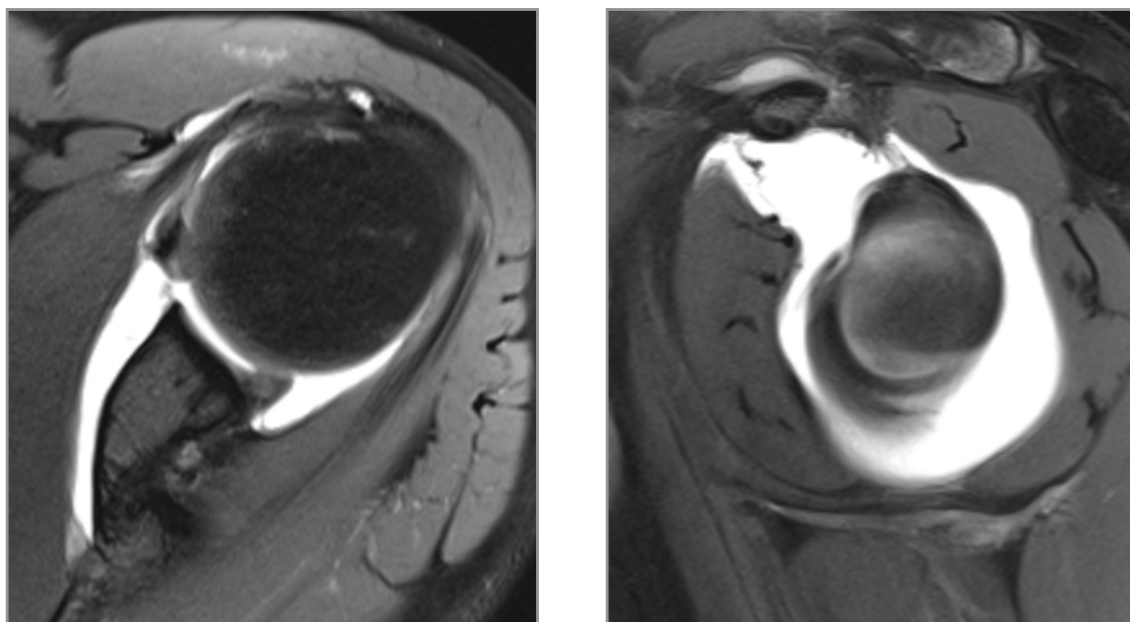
Shoulder MRI arthrography – T1-weighted TSE with fat suppression (FS). Axial (A) and sagittal (B) images demonstrating absence of labrum and a thickened middle glenohumeral ligament. MRI, magnetic resonance imaging.
